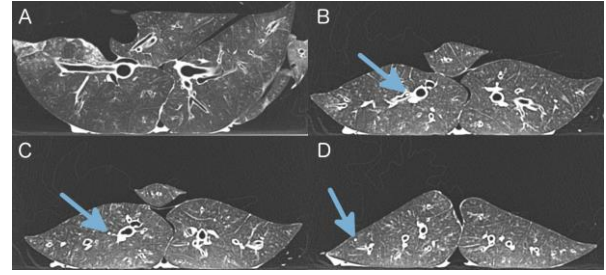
CT scans of the inflated lung, (A) prior to inserting the robot, (B) prior to the pneumatic puncture, (C) after the pneumatic puncture, and (D) after deployment of the steerable needle to the lung periphery. The blue arrows point to the robot.
